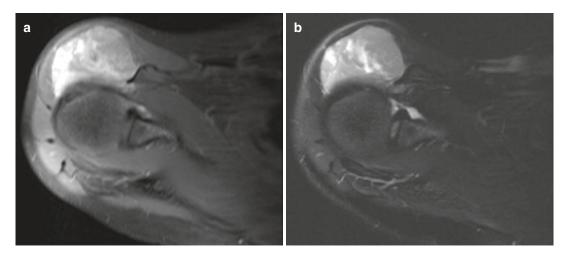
Synovial sarcoma in a 16-year-old-girl. Axial (a) FS T2-weighted and (b) CE FS T1-weighted MR images show a heterogeneous, partially enhancing mass in the soft tissues anterior of the shoulder
